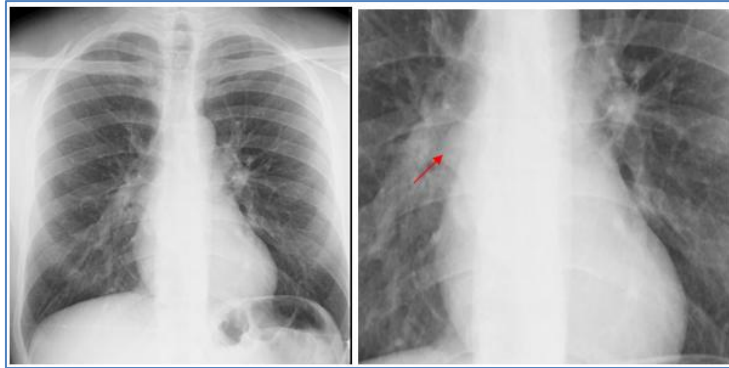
Chest x-ray showing a mediastinal oval mass of hydric tonality (arrow)
